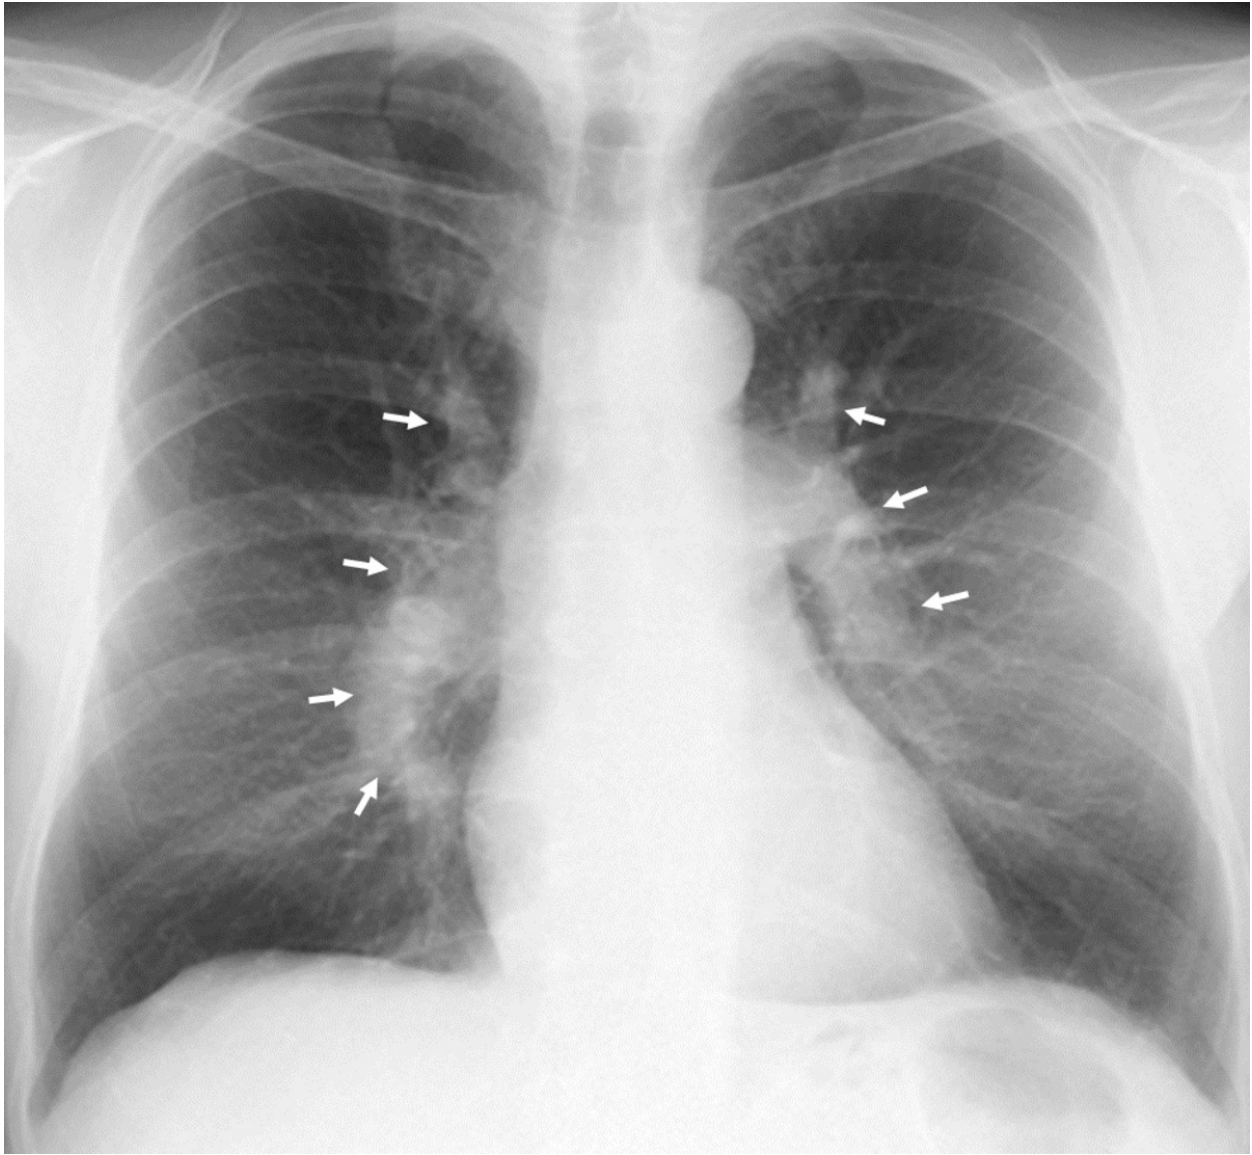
The chest radiograph demonstrates a bilateral increase in the hilar size (white arrows). The hilar convergence sign confirms the vascular origin of hilar enlargement. There is peripheral oligoemia and normal cardiac silhouette size. The patient had Pulmonary Arterial Hypertension.
